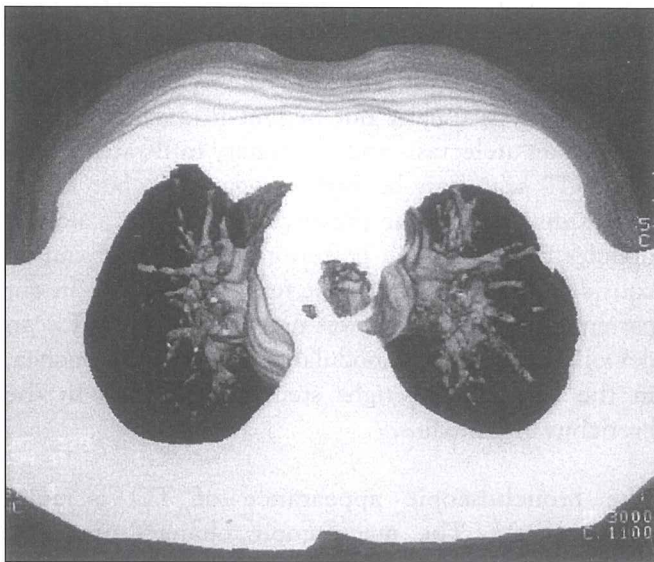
The three-dimensional helical CT showing distortion and nodular infiltration in the tracheal lumen.
